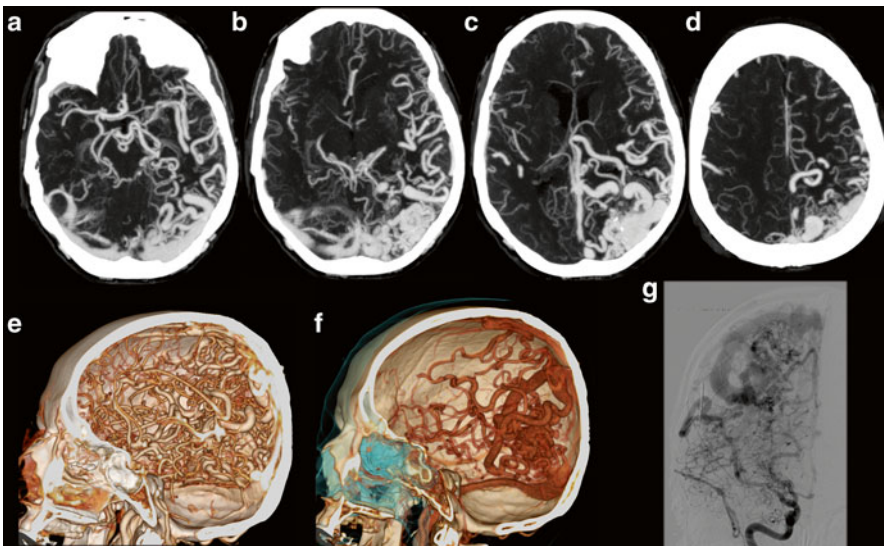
A 56 y/o female presented initially with a seizure due to a large dural AV fistula. Consequently she was admitted to the emergency room with a large intracranial hemorrhage. Shown here are the VR images of the CTA (e and f), the MIP (a–d) images, and DSA images (g). The MIP images are helpful to determine the full extent of the vascular malformation, which is more complicated in VR CTA. However, dynamic information from i.a. DSA is needed. Shown is a large vascular malformation with multiple small arterial feeders and dilated (cortical) veins. DSA shows the main feeder from the external meningeal artery
